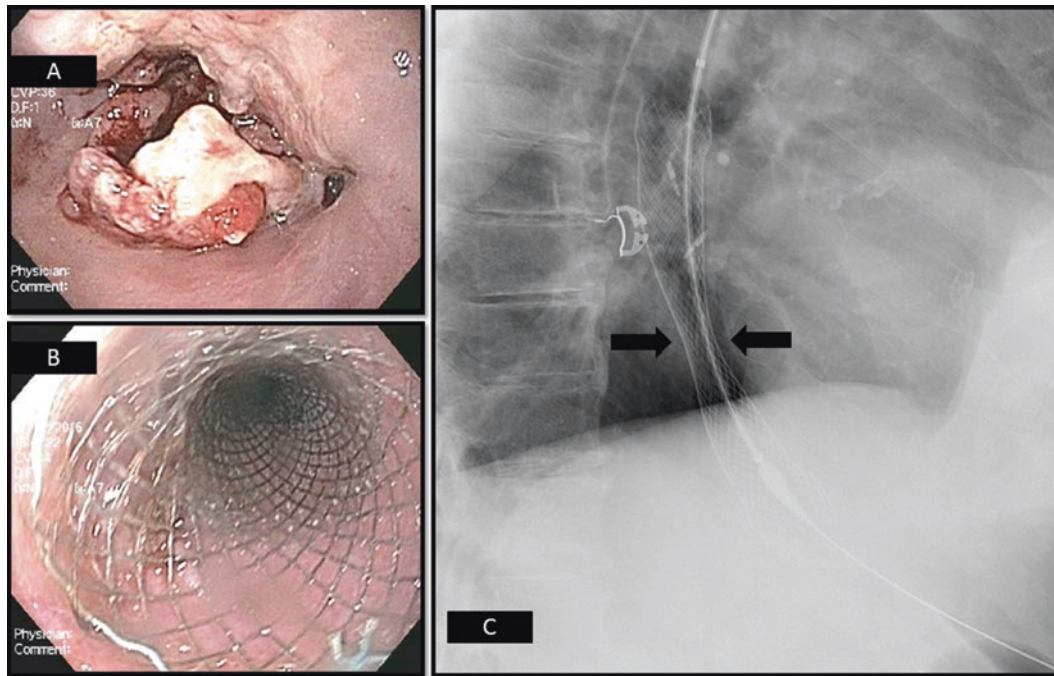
Endoscopic (a) and (b) and radiographic views (c) of a partially covered SEMS for an esophageal adenocarcinoma (arrows highlight tumor preventing full stent expansion after deployment)
